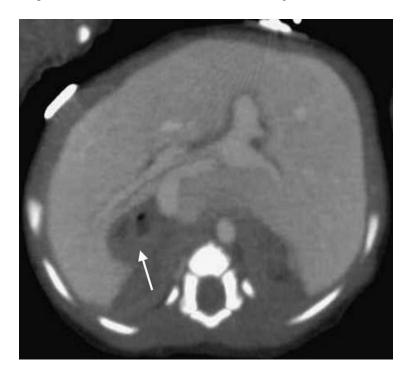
CT axial image of 1 month old girl with huge transverse liver and right side stomach (white arrow). No definite spleen can be found in the abdomen. Situs ambiguous is suspected and {A,_,_}} is assigned
